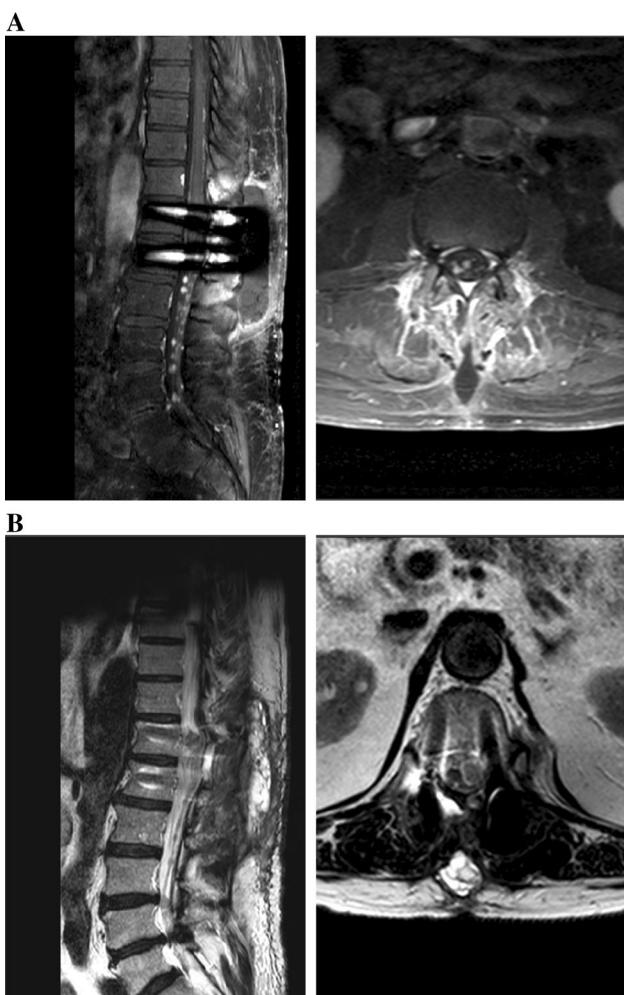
MRI at a 3-month follow-up: a T2-weighted enhanced axial and sagittal views showing a regional recurrence, with multi-metastatic dissemination to the entire cauda equina and b T2-weighted enhanced axial and sagittal views showing a local recurrence
